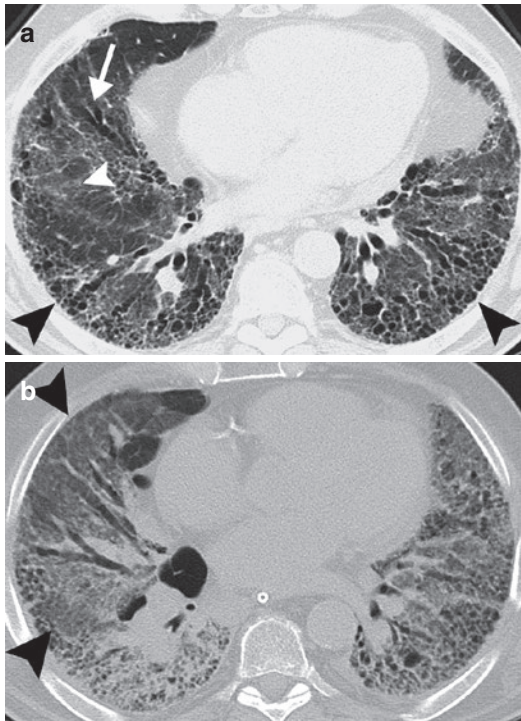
(a, b) Axial CT image in a 63-year-old man with usual interstitial pneumonia (UIP)/idiopathic pulmonary fibrosis (IPF) shows bilateral reticular opacities, honeycombing (*black arrowheads*), and traction bronchiectasis (*arrow*). In addition, patchy ground-glass opacities are present (*white arrowheads*) (a). Acute exacerbation in the same patient shows marked progression of ground-glass opacities (*arrowheads*) (b)
